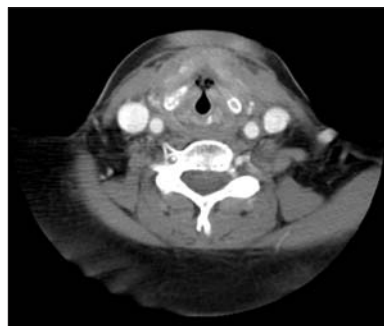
Computed tomography taken 1 month after conclusion of the protocol for concurrent radiation therapy and chemotherapy.
